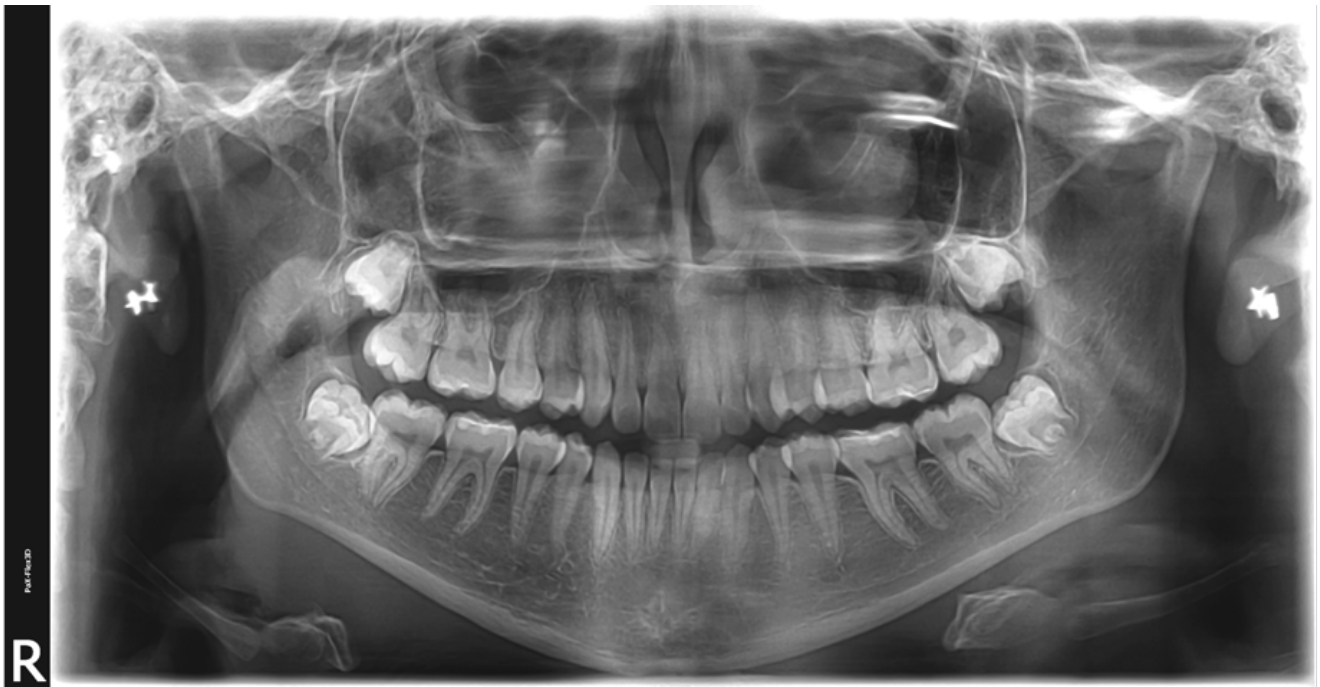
Panoramic X-Ray showed no recurrence four years later.
